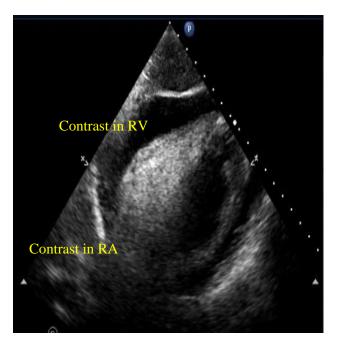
Saline contrast through pericardiocentesis sheath filling right atrium and right ventricle on echocardiography.
